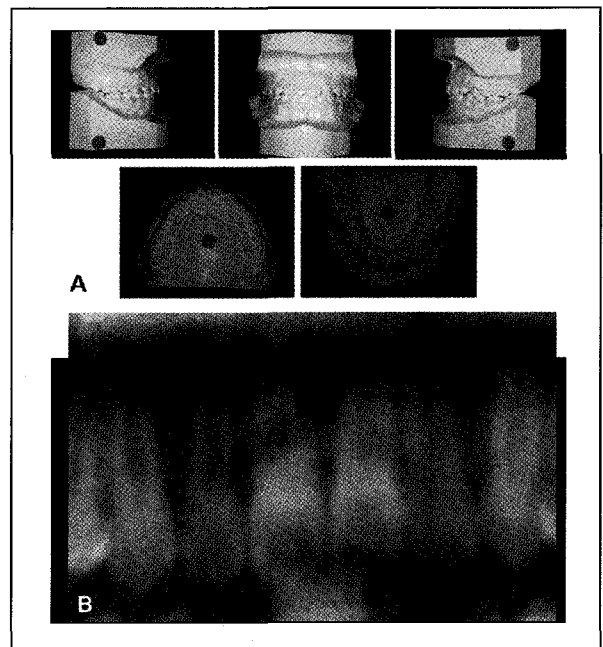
Posttreatment study models (A) and panoramic radiographs (B).
